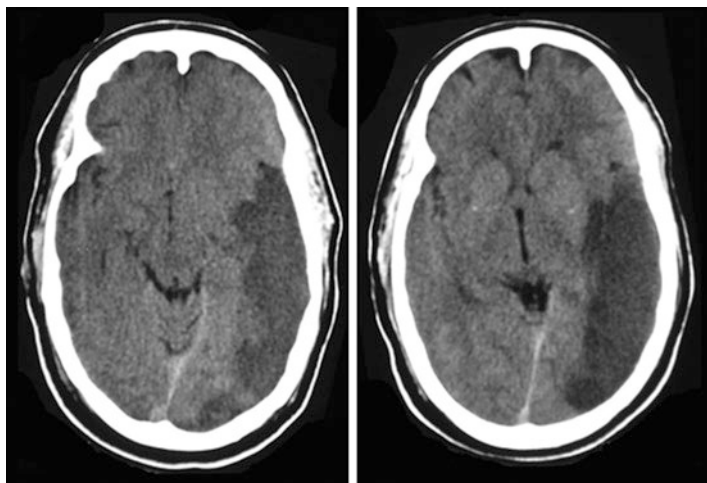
CT scan showing low density from left middle cerebral artery posterior division infarct
